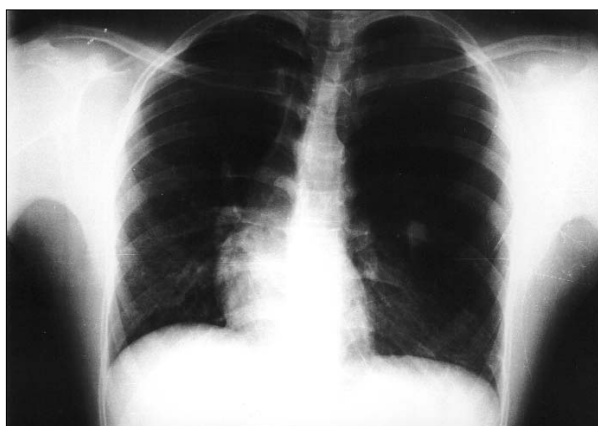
Chest-X-ray of the same patient on expiration shows the air trapping at the left upper lobe and the contralateral mediastinal shift.
